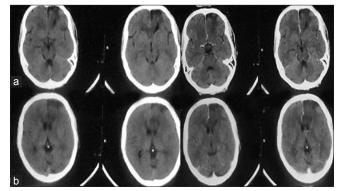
Follow-up computed tomography Scan of head after completion of radiotherapy (a) Plain and (b) Contrast study showed no residual tumor or recurrence
